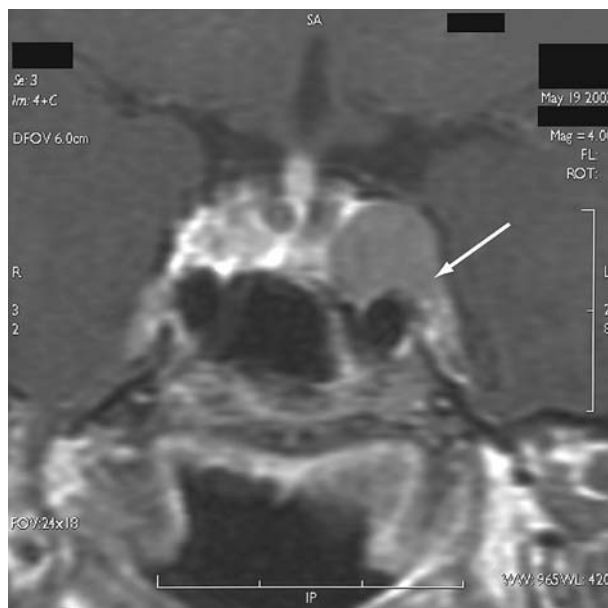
MR (T1-weighted) scan showing the residual hypophyseal adenoma before gamma knife surgery. The adenoma infiltrates the left cavernous sinus (arrow). The volume of the adenoma was computed to be 1.5 cm
